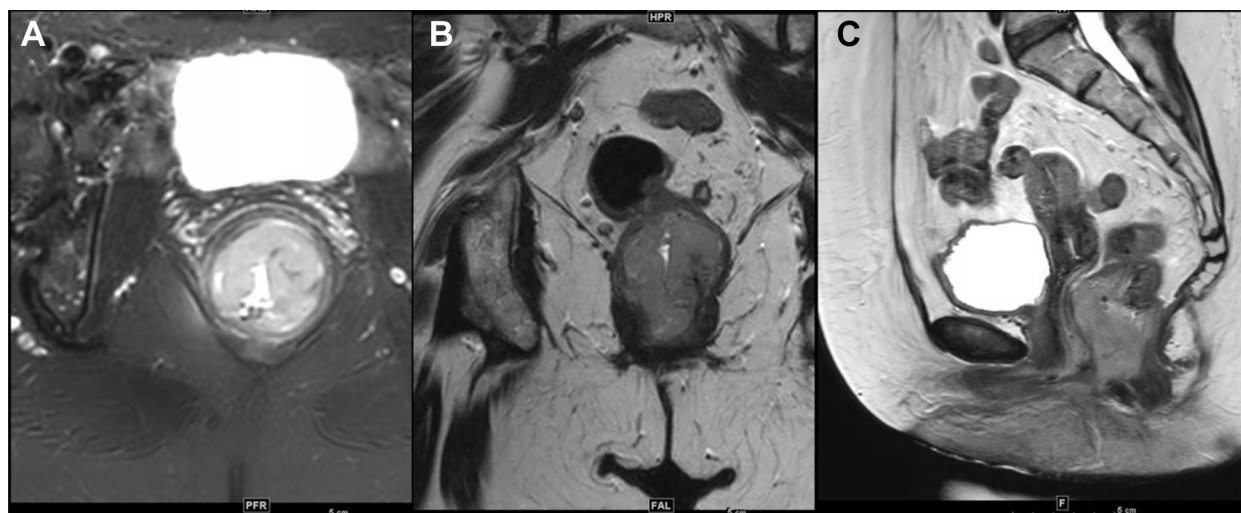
Preradiation therapy (RT) magnetic resonance imaging (MRI) with contrast (A = axial, B = coronal, C = sagittal).
